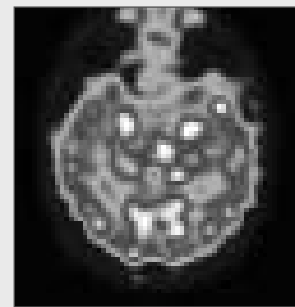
Left mesial temporal lobe seizure, showing bilateral changes on postictal SPECT. Injection of HMPAO was 60 seconds after termination of the ictal discharge. Image shows a single axial slice in the plane of the long axis of the temporal lobe. There is bilateral hypoperfusion of the temporal lobes with small foci of persisting hyperperfusion in the mesial temporal cortex on both sides.
